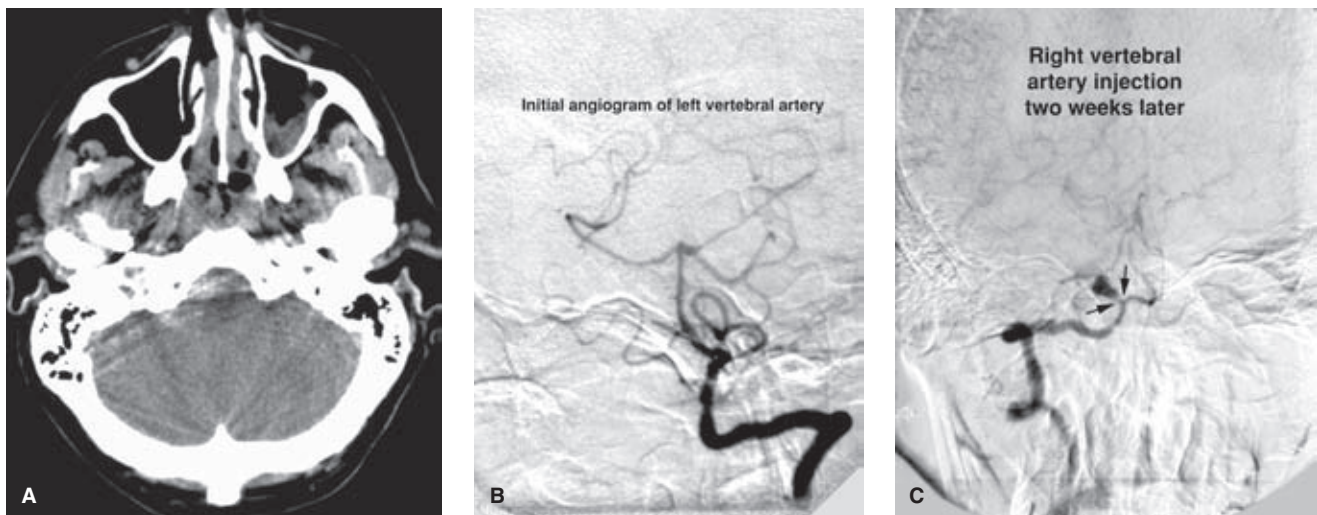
(A–C) Angiographically negative subarachnoid hemorrhage III: importance of the distal right vertebral artery and right posterior inferior cerebellar artery. An elderly male was admitted to the hospital with Grade II subarachnoid hemorrhage and a preponderance of blood on the right side of the posterior fossa (A). This CT appearance should prompt particular suspicion about the right posterior inferior cerebellar artery. Its omission from angiographic interrogation constitutes a major, and in this case fatal, oversight. Moreover, in the setting of a posterior fossa hemorrhage in which the right posterior inferior cerebellar artery origin has been seen by reflux, the possibility of a subarachnoid dissection of the right vertebral artery should not be forgotten when no other explanation for subarachnoid hemorrhage has been found. The initial angiogram (B) of the posterior fossa was performed via the left vertebral artery only, an injection that did not opacify the distal right vertebral artery. The patient made a complete clinical recovery. A follow-up angiogram (C) 2 weeks later included an injection of the right vertebral artery. This demonstrated an aneurysm of the origin of the right posterior inferior cerebellar artery (arrows). The patient was immediately scheduled for treatment, but the aneurysm ruptured fatally the next day.
